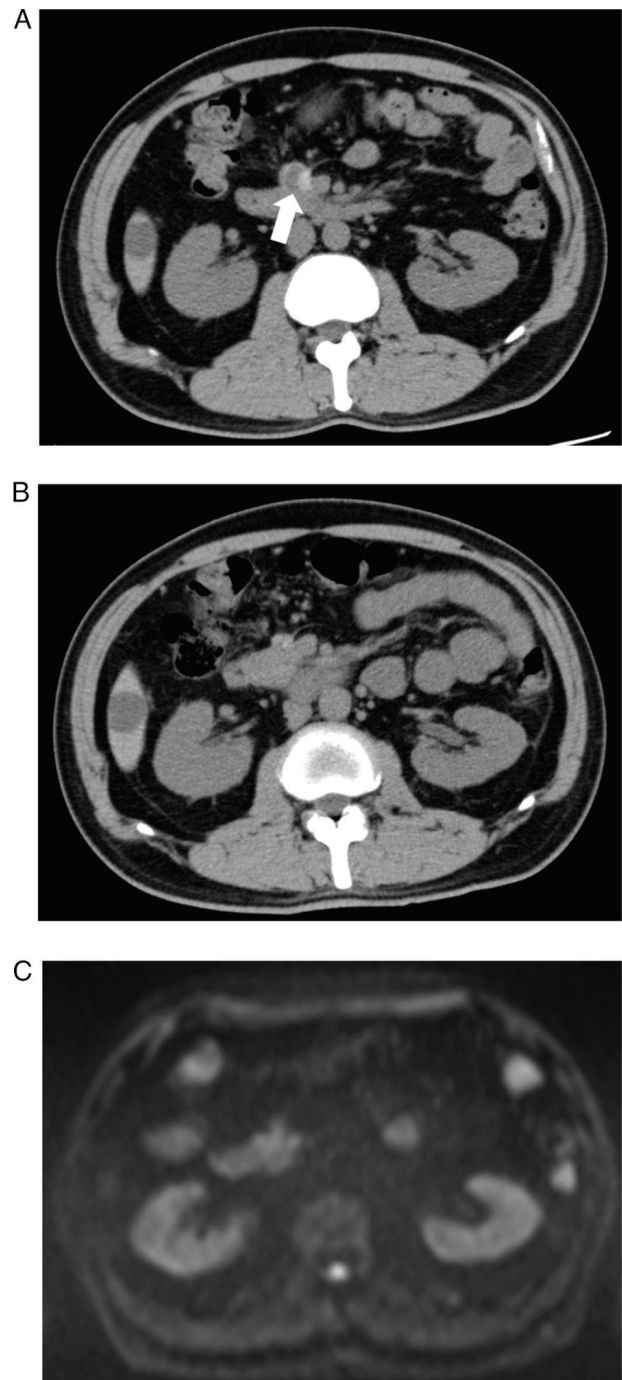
(A) Computed tomography after 8 cycles of doxorubicin. (B) Computed tomography 3 years after starting pazopanib. The white arrow-head indicates the retroperitoneal primary tumour. (C) Magnetic resonance imaging (diffusion-weighted imaging) after 3 years of pazopanib initiation.
